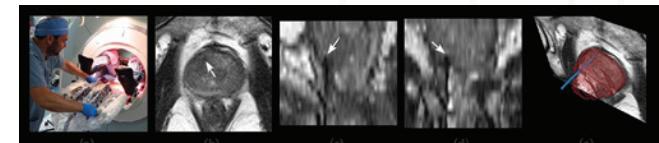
Finding Needles in transperineal in-gantry prostate biopsy. (a) The patient is placed in the supine position in the MRI gantry, and his legs are elevated to allow for transperineal access. The skin of the perineum is prepared and draped in a sterile manner, and the needle guidance template is positioned. (b), (c) and (d): Axial, sagittal and coronal views of intraprocedural T2-W MRI with needle tip marked by white arrow. (e) 3D rendering of the needle (blue), segmented by our method, and visualized relative to the prostate gland (purple), and an MRI cross-section that is orthogonal to the plane containing the needle tip.
